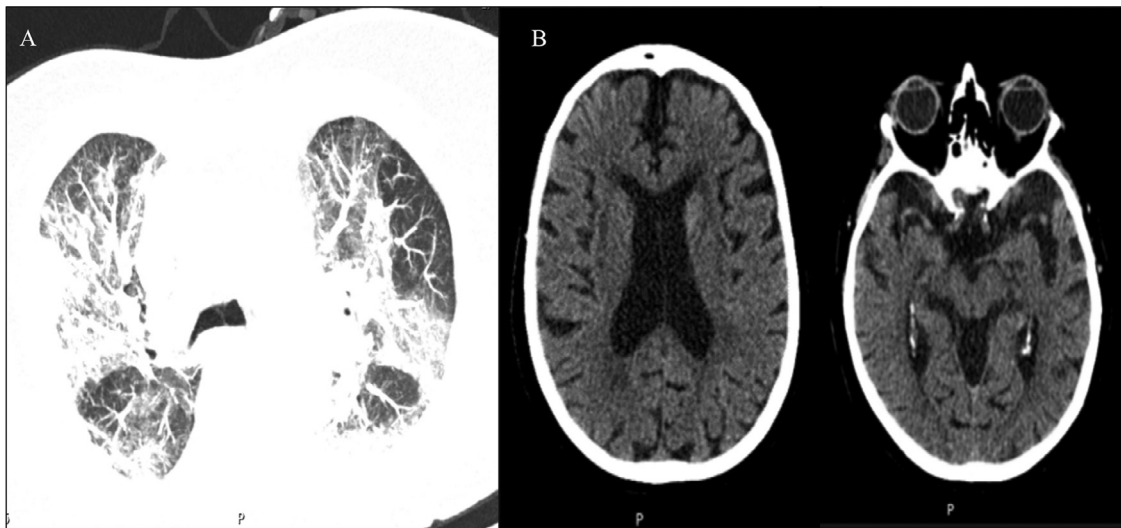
A. Lung CT scan: SARS-CoV-2 organizing pneumonia. B. Cranial CT scan: Chronic ischemic microvascular leukoencephalopathy and generalized brain atrophy.
